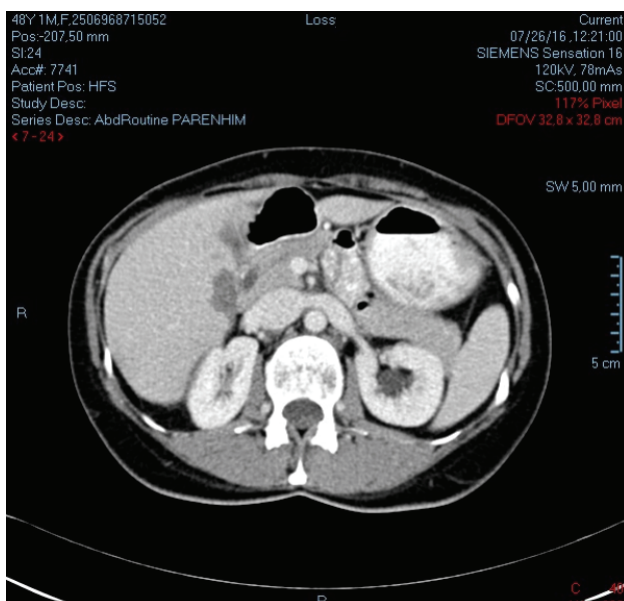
Normal computed tomography (CT) of abdominal organs.
